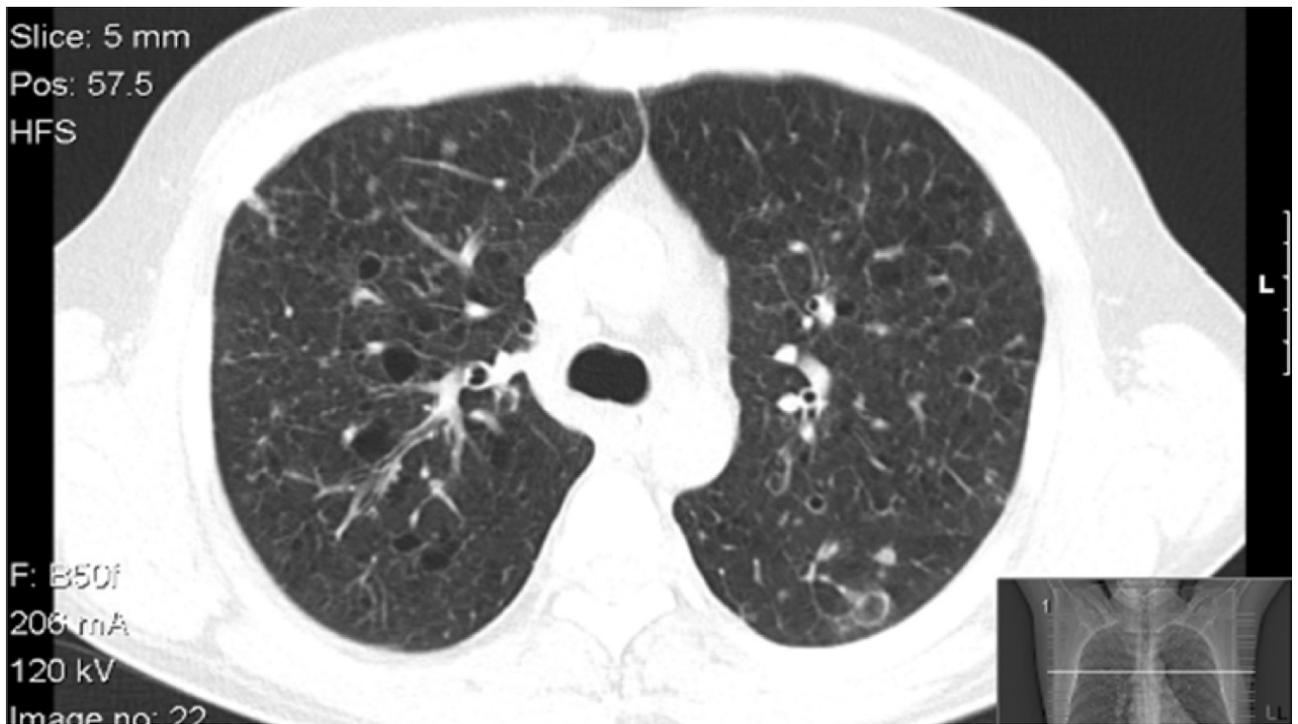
CT-scan from a patient with LCH and lung involvement. The image shows a honeycomb pattern.
